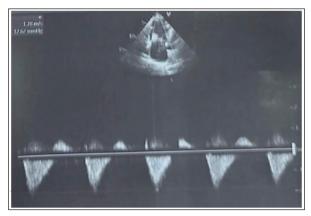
(b): Echocardiogram showing Severe TR
